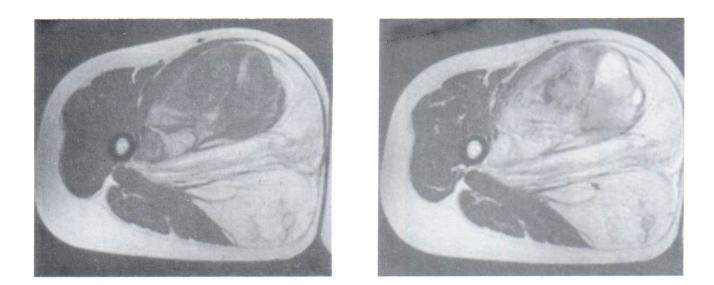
Liposarcoma in the thigh of a 45 year old Chinese female. MR shows a large mass involving the adductor compartment which has heterogeneous signal characteristics. There are large areas of high signal on the (a) axial T1-weighted sequence (SE 750/15) and intermediate to high signal on (b) T2-weighted (SE 2024/60) sequences similar to the signal seen in the subcutaneous fat. In addition, there is an area which is of low signal on T1-weighted sequences and high signal on T2-weighted sequences. The findings were highly suggestive of a liposarcoma.
